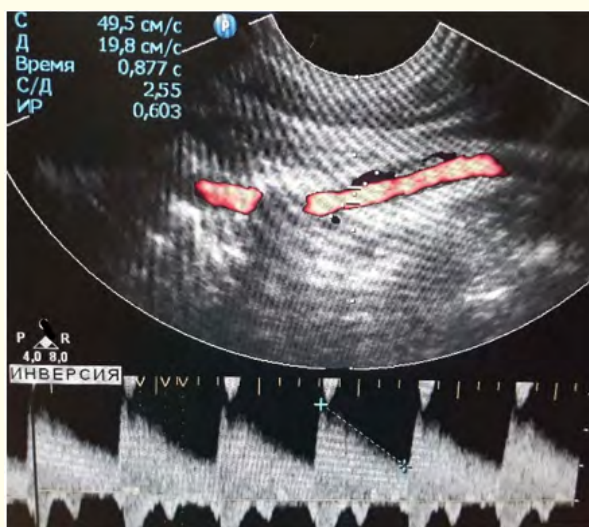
Doppler spectrum of the blood flow in first segment of the vertebral artery in neutral position of patient. Vs is 49,5 cm/c, RI - 0,60.
